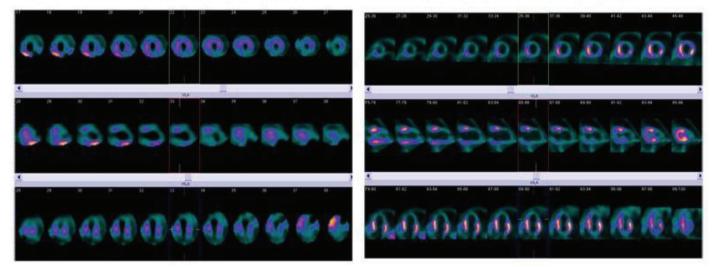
MIBI and PET/CT of case 1
